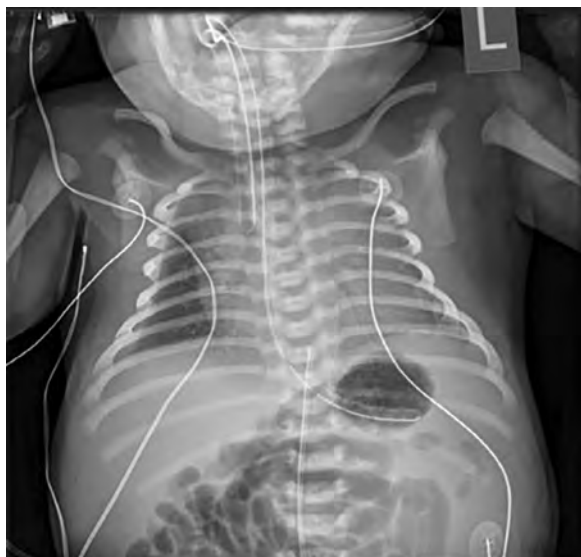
Plain radiograph of a 5-day-old infant with posterior urethral valves and bronchopulmonary dysplasia, requiring airway support, shows reduced lung volume and left upper and lower lobe atelectasis.
